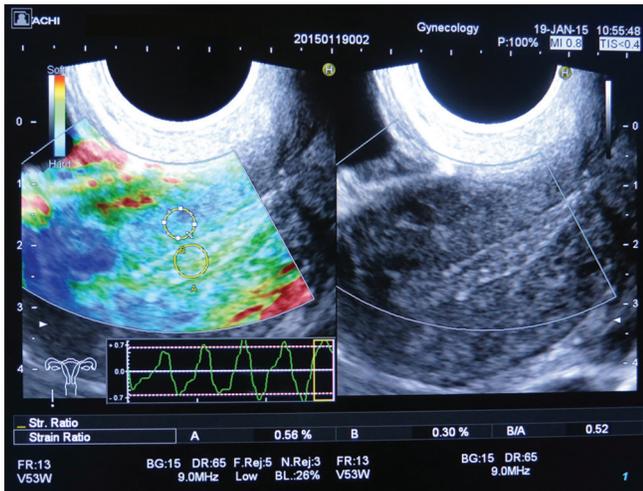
Elastosonography technique
